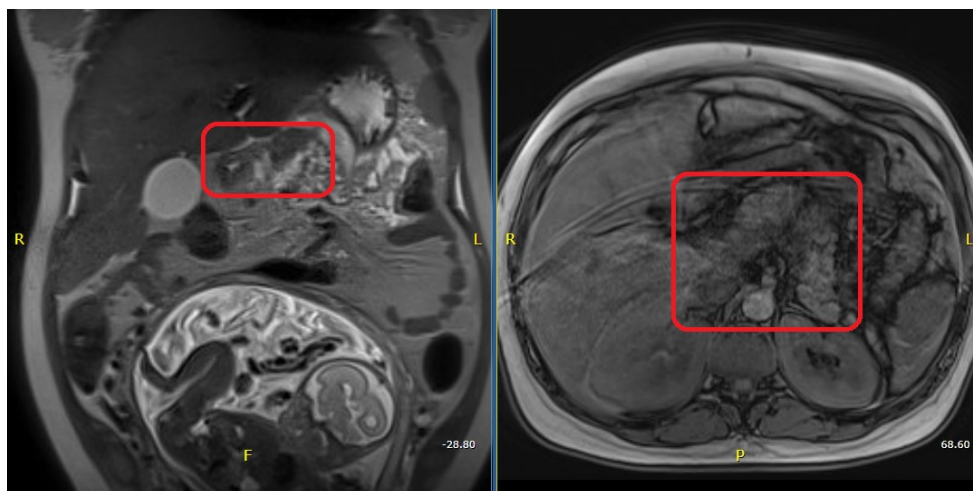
MRI-imaging. A frontal and transversal view of the pregnant woman with pancreatitis. The red outline indicates the pancreas.
